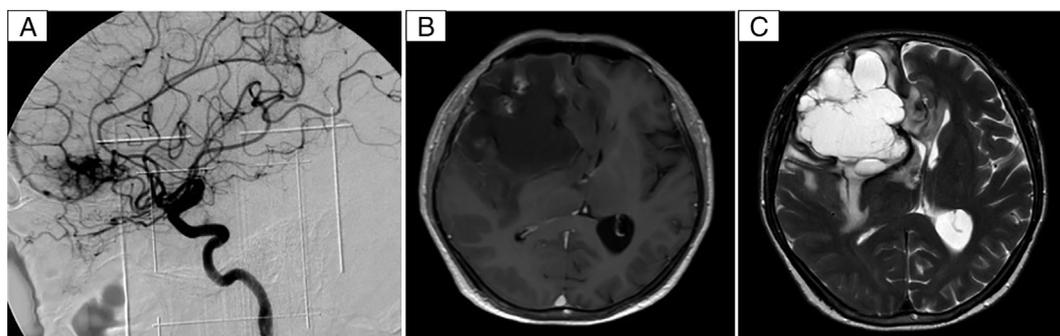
(A) Lateral view of right internal carotid angiogram in arterial phase. There is a basifrontal cAVM with no deep venous drainage. Representative post-contrast T1-weighted (B) and T2-weighted (C) images of in axial view. Both images show a large, heterogenous multi-loculated cystic area with a small, solid component within the lesion. This lesion is centred in the right frontal lobe where the cAVM previously was. This lesion has causative mass effect, perilesional oedema and midline shift.
